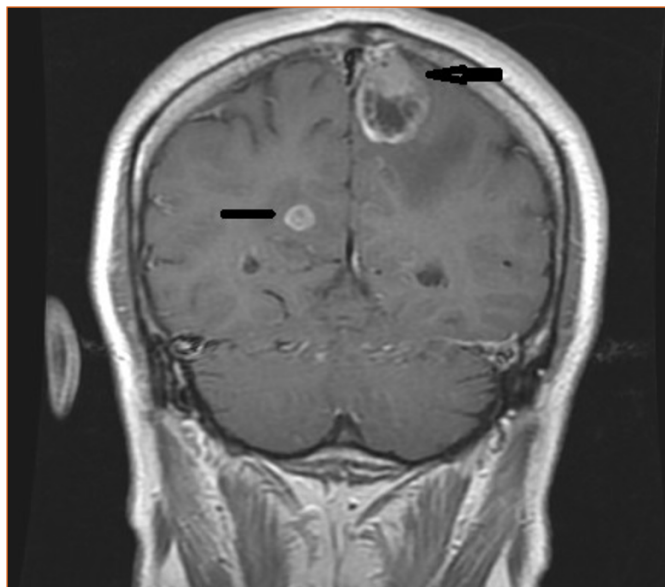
Paramedian midline metastatic lesion in the left posterior parietal region (brain MRI)
